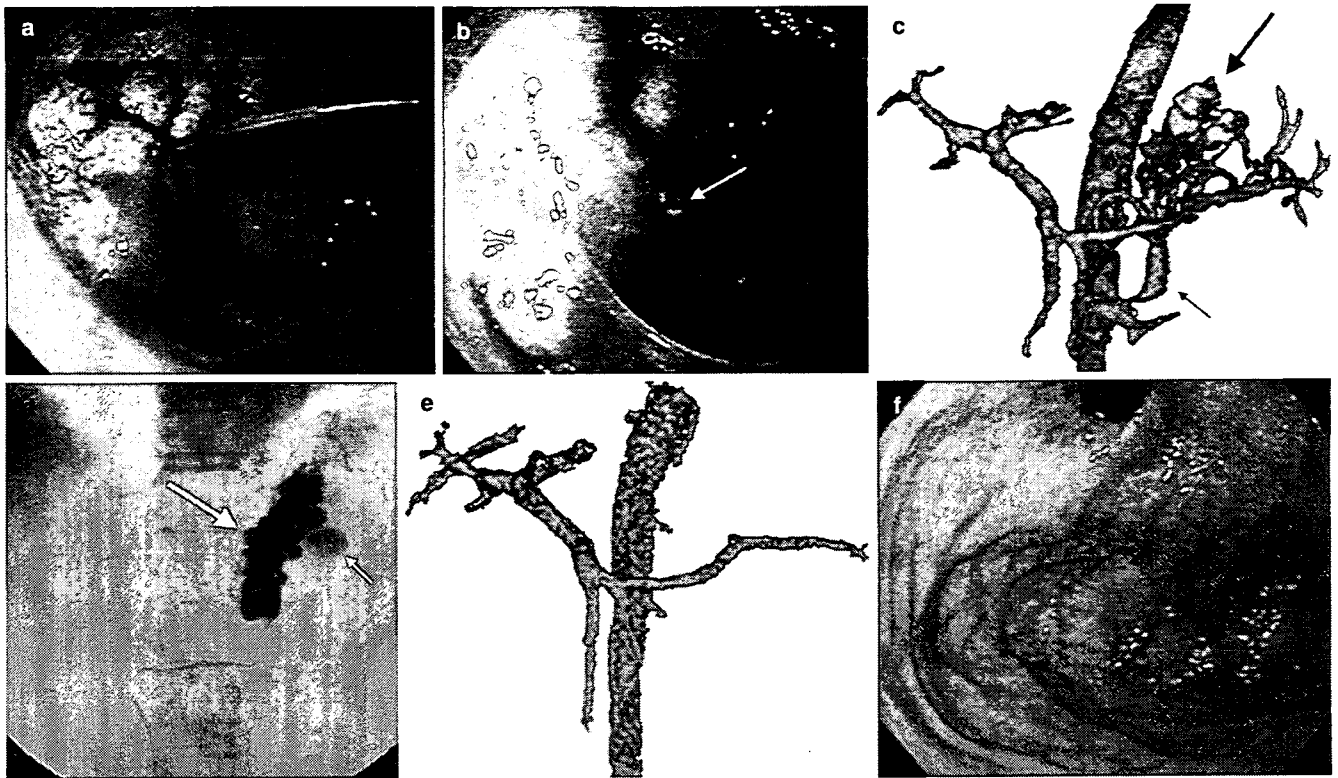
A 78-year-old man with alcoholic liver cirrhosis. a Endoscopic examination reveals huge gastric fundal varices with spurting bleeding. b After cyanoacrylate glue was injected intravariceally, gastric variceal bleeding stopped and the glue spilled from the rupture site (*arrow*). c Three-dimensional computed tomography (CT) portogram a few hours after endoscopic treatment reveals gastric varices (*large arrow*) and a gastroduodenal shunt (*small arrow*). d Venogram shows retrograde obliteration. Gastric fundic varices (*large arrow*) were completely obliterated by 5% ethanolamine oleate injected in retrograde manner during balloon occlusion. Subsequently, the posterior gastric vein (*small arrow*) was opacified in retrograde manner. e Three-dimensional CT portogram obtained 1 week after balloon-occluded retrograde transvenous obliteration (B-RTO) reveals disappearance of the gastric varices and gastroduodenal shunt. f Endoscopic examination obtained 1 year after B-RTO reveals complete eradication of the gastric varices
